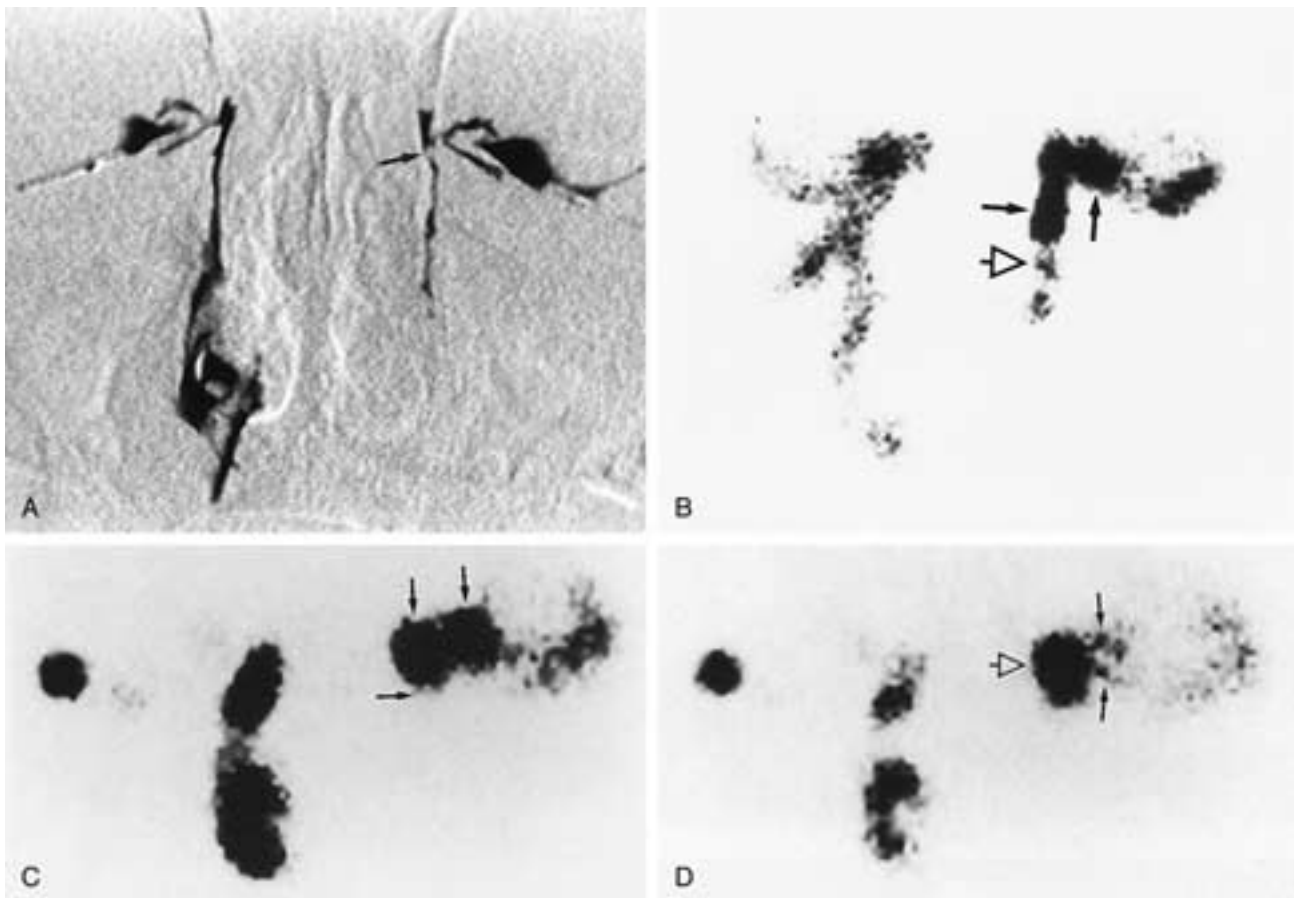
Comparison of DCG and DSG. A and B, Patient with left epiphora. A, DCG of the normal right side. Small filling defect of the distal left lacrimal sac (arrow) with delayed drainage into the nasolacrimal duct. B, DSG at 20 minutes. Normal drainage on the right side with decreased isotope activity within the NLDS. Persistent increased activity within the left lacrimal sac and canaliculi (solid arrows) with minimal activity entering the nasolacrimal duct (open arrow). C and D, Patient with left epiphora and a bloody discharge from the left tear duct. C, DSG at 15 minutes. Inferior portion of the left lacrimal sac is not seen (horizontal arrow). Increased activity in the proximal lacrimal sac and canaliculi (vertical arrows). Normal right drainage. D, Post-rub DSG. Decreased activity in the right NLDS. Persistent increased activity in the left lacrimal sac (open arrow), superior canaliculus, and inferior canaliculus (solid arrows) caused by obstruction to outflow in the left lacrimal sac. Dacryolith in the left lacrimal sac. (See Fig. 10-18A-C for DCG and CT of the same patient.)
